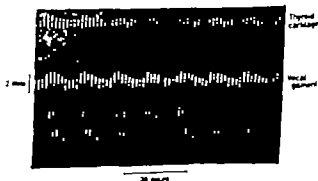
Ultrasonic recording of the vibrating vocal fold obtained with the apparatus shown in Fig. 2.
